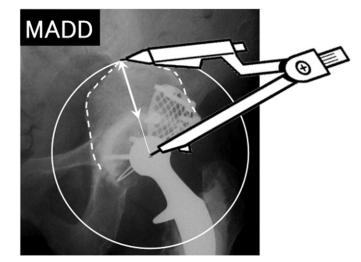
Maximum acetabular defect distance (MADD). The MADD was evaluated using the postoperative radiograph as the distance between the furthest point of the bone defect margin and the outer margin of the cup from the femoral head center.
